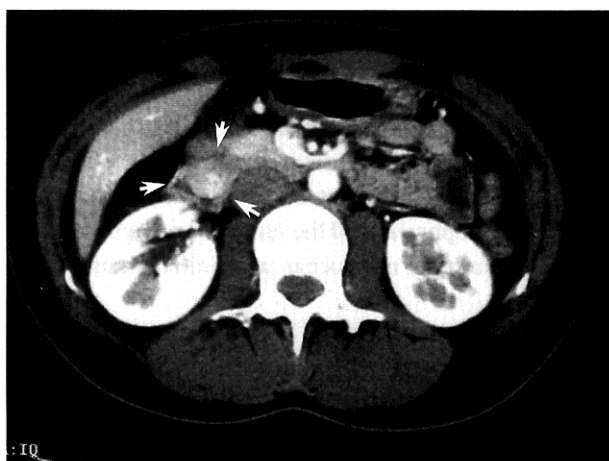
Abdominal CT. Submucosal tumor of the duodenum was enhanced.
